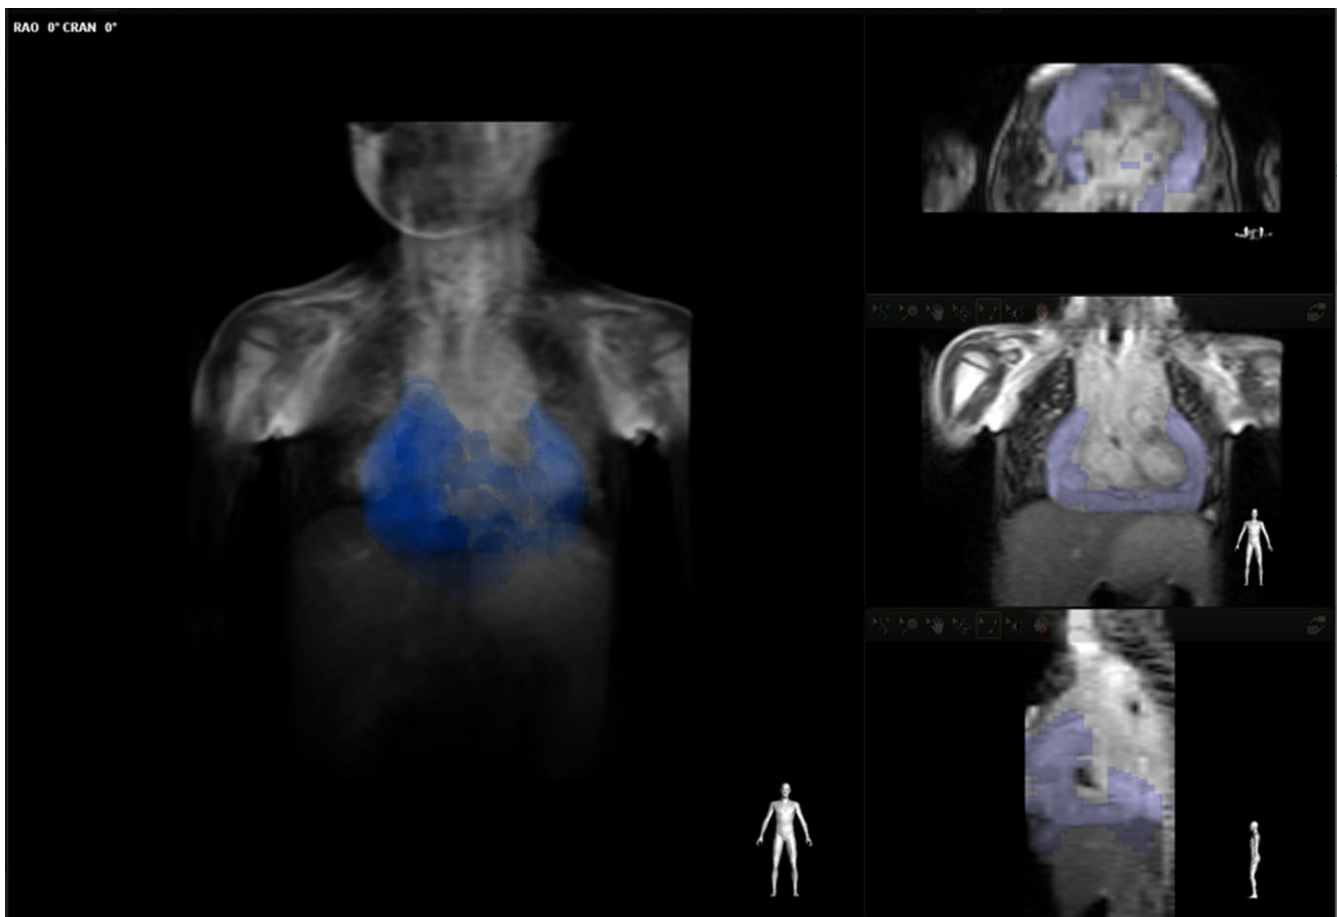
VesselNavigator allowed use of 3D anatomical information from patient's existing MRA dataset as a 3D roadmap overlay on a live X-ray image allowing visualization of loculations in the pericardial space during the procedure.
